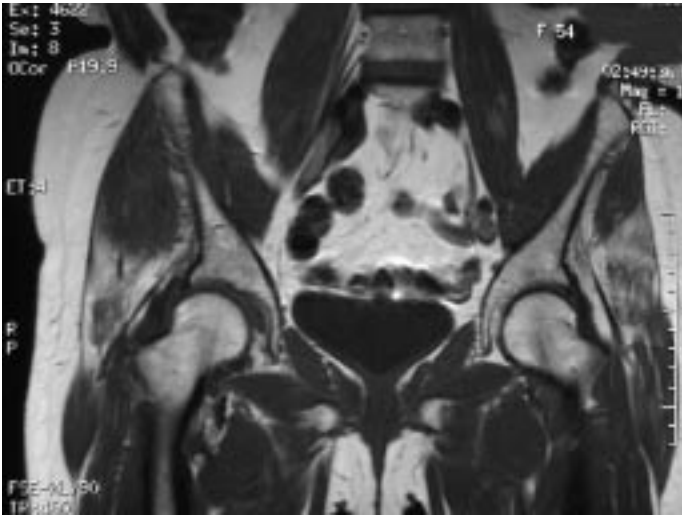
MRI showing the ligamentum teres in the acetabulum and widening of the joint space of the right hip.
